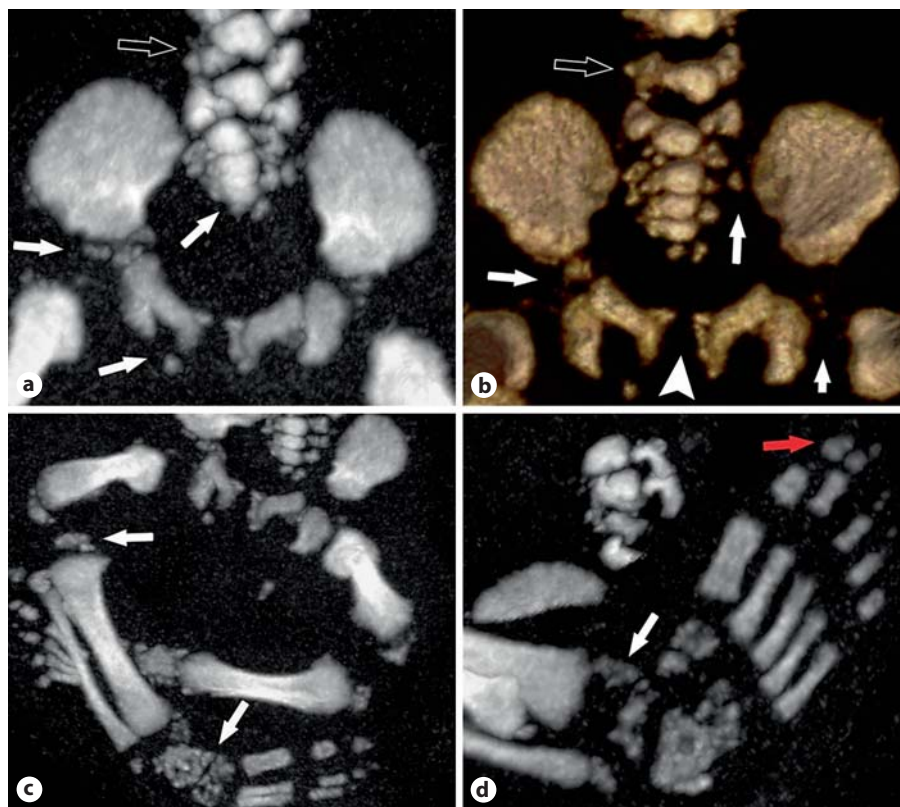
Case 5: chondrodysplasia punctata. a 3D-CT MIP. b 3D reconstructions of pelvic bones showing sacral body malformation (open arrow) and punctate calcifications in the sacrum, triradiate cartilage, ischium and pubis (white arrows). Notice widening of the symphysis (arrowhead). c MIP reconstruction of pelvis and lower limbs. Rhizomelic shortening of long bones and punctate calcifications on the knee and tarsum (arrows). d MIP reconstruction of a foot shows tarsal calcifications (white arrow) and distal phalangeal hypoplasia (red arrow, online version only).
